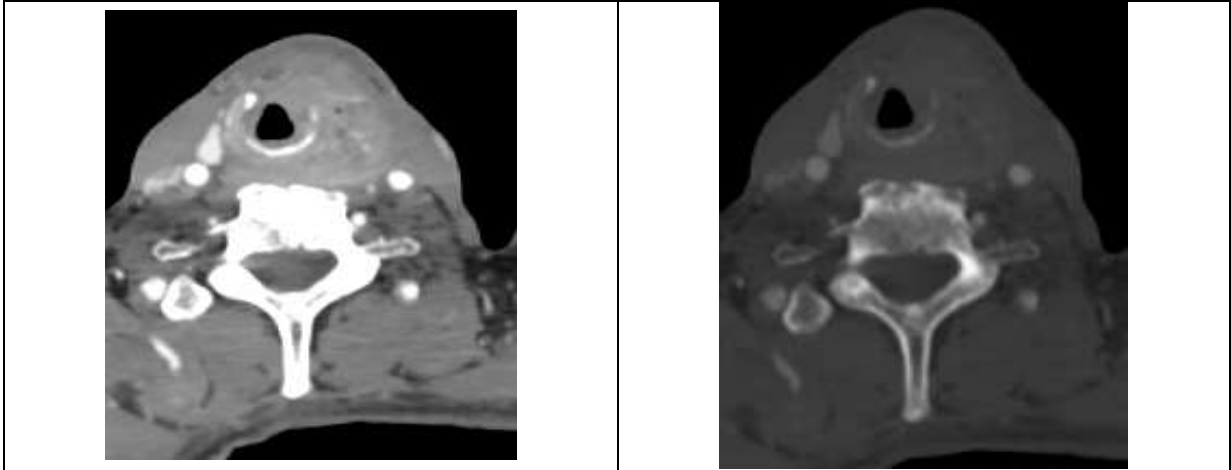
(a) and 9(b): Axial CECT and CT bone images at the level of cricoid cartilage in a case of Ca transglottis shows invasion of cricoid cartilage and penetration of lesion into extralaryngeal space
